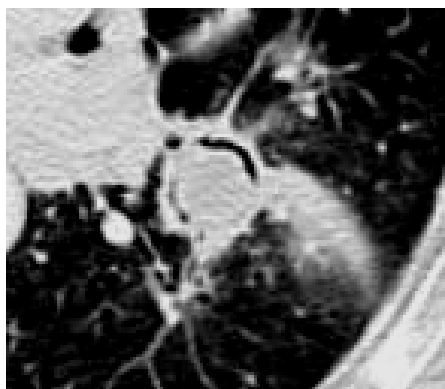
Axial CT, lung window zoomed up image at the level the left pulmonary artery reveals a cavitary lesion at apical segment of lower lobe of left lung with a soft tissue density mass seen with air crescent sign. There is adjacent ground glass opacity, CT halo sign proved to be fungal infection.
